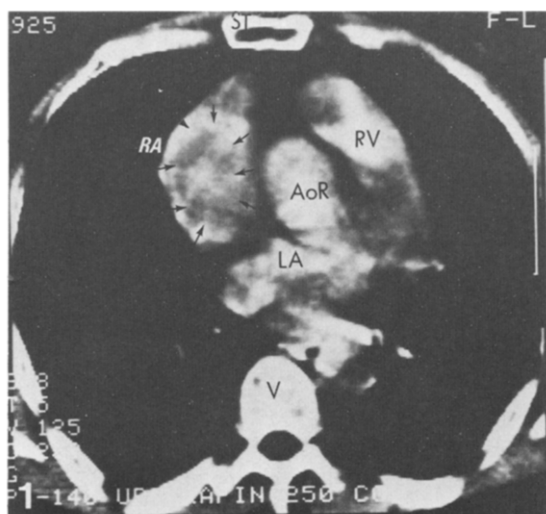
Case No. 1: patient with a right atrial myxoma. CT scanning at the level of the aortic root shows a space-occupying lesion in the right atrium (arrows).
